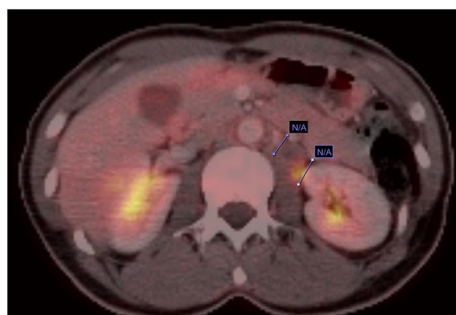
A Pet-CT scan showed a doubtful uptake in retroperitoneal lesion.
